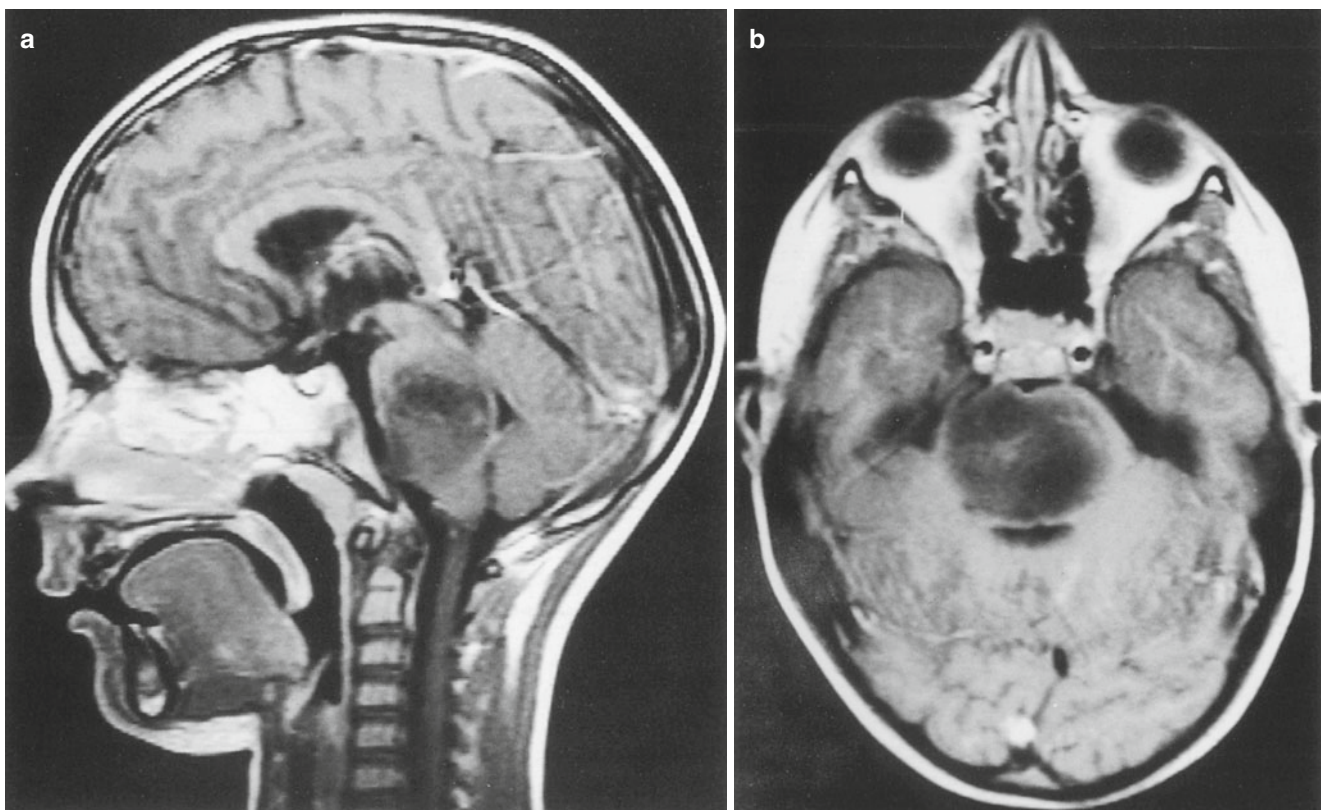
(a) Sagittal and (b) axial T1-weighted MRI with gadolinium showing massive expansion of the pons by a poorly enhancing tumor – characteristic of a diffuse pontine glioma
